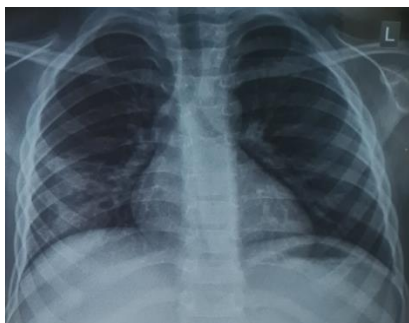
Chest X-ray on admission: Round consolidation in the right low lung lobus
